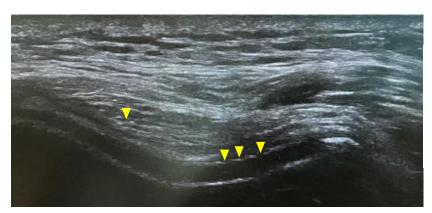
Suprapatellar transverse ultrasound scan of right knee demonstrating double contour sign indicated by arrow heads.
